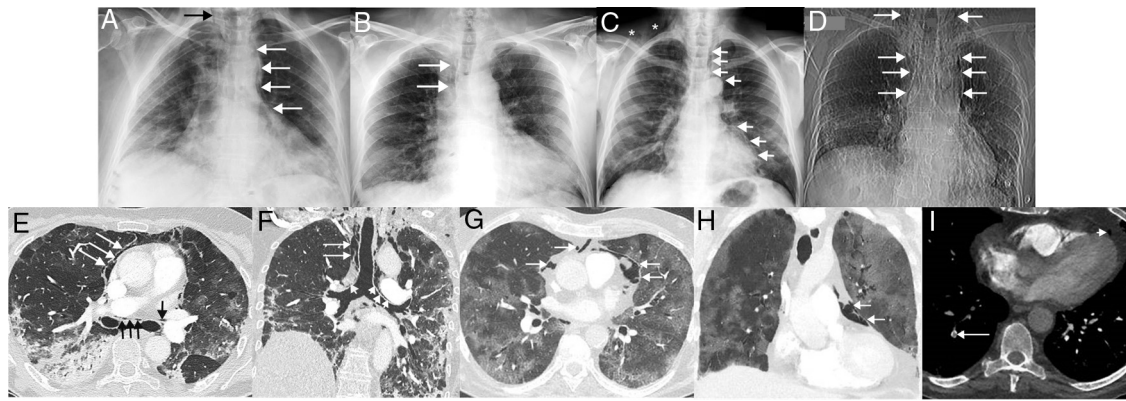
(A) Posteroanterior chest X-ray in a 60-year-old woman admitted with bilateral SARS-CoV-2 pneumonia showing incidental pneumomediastinum (white arrows). Note the spread of gas to the soft tissue of the neck (black arrow). (B) Posteroanterior chest X-ray in a 62-year-old man admitted with bilateral SARS-CoV-2 pneumonia, who presented chest pain and dyspnea. Right paratracheal pneumomediastinum (arrows) is seen on the X-ray. (C) Posteroanterior chest X-ray in a 58-year-old man with bilateral SARS-CoV-2 pneumonia, who had an episode of chest pain and hypotension. On the X-ray, pneumomediastinum with pneumopericardium (arrow) and gas is seen in the soft tissue of the right supraclavicular region (asterisks). (D) Topogram (corresponding to a chest CT scan) of the only CT-diagnosed pneumomediastinum in a 64-year-old woman with bilateral SARS-CoV-2 pneumonia, who presented with chest pain and dyspnea. The topogram shows a large pneumomediastinum extending to the soft tissue of the neck (arrows). (E) Axial CT image of the chest (lung window) of the patient in image D confirming the presence of ectopic gas surrounding the main bronchi (black arrows) and dissecting the pericardium (white arrows). (F) Coronal chest CT image (lung window) of patient in image D in which air can be seen dissecting both main bronchi (short arrows) and right paratracheal fatty tissue (long arrows). (G) Axial chest CT image (lung window) of patient in image B confirming the presence of gas dissecting the pericardium (arrows). (H) Coronal chest CT image (lung window) of the patient in image B showing gas dissecting the pericardium (arrows). (I) Axial CT image of the chest (mediastinum window) of the patient in image B, identifying a defect in a subsegmental artery in the right lower lobe (long arrow). Note the presence of gas in pericardial fat (short arrow).
